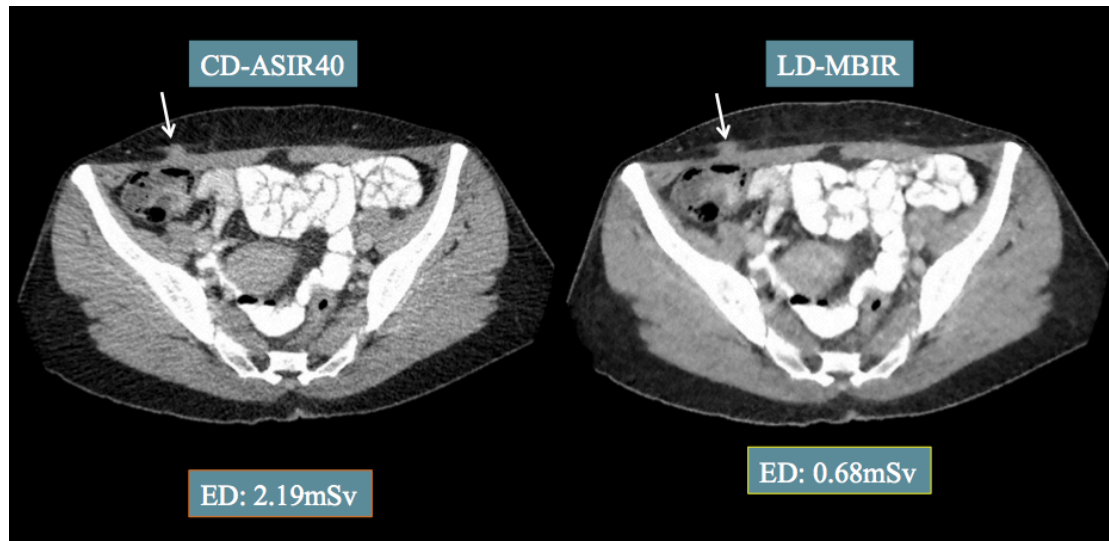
CD ASIR and LD MBIR axial CT images in a 42 year-old female patient presenting with acute abdominal pain. Both images show a subcutaneous nodule of indeterminate significance superficial to the lateral margin of the right rectus abdominis muscle. The LD MBIR image was acquired at a significantly lower dose than the CD ASIR image. The nodule was not detected by reviewer 1 on the LD MBIR images.
